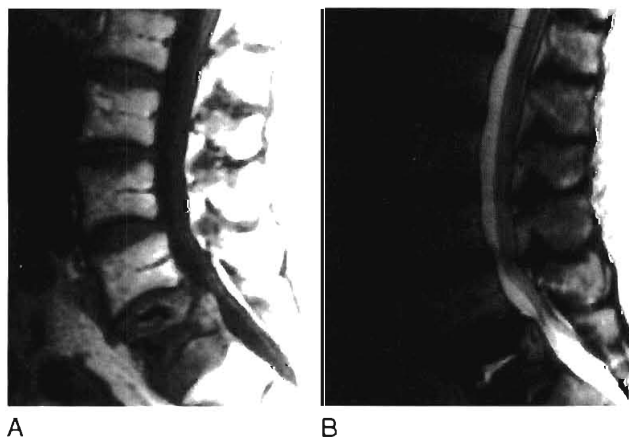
Benign compression fracture. Sagittal T1-weighted (*A*) and T2-weighted (*B*) MRI scans demonstrate a compression fracture of L5. Compare the signal characteristics of the remaining bony elements and pedicles with the signal of the normal bony structures.
